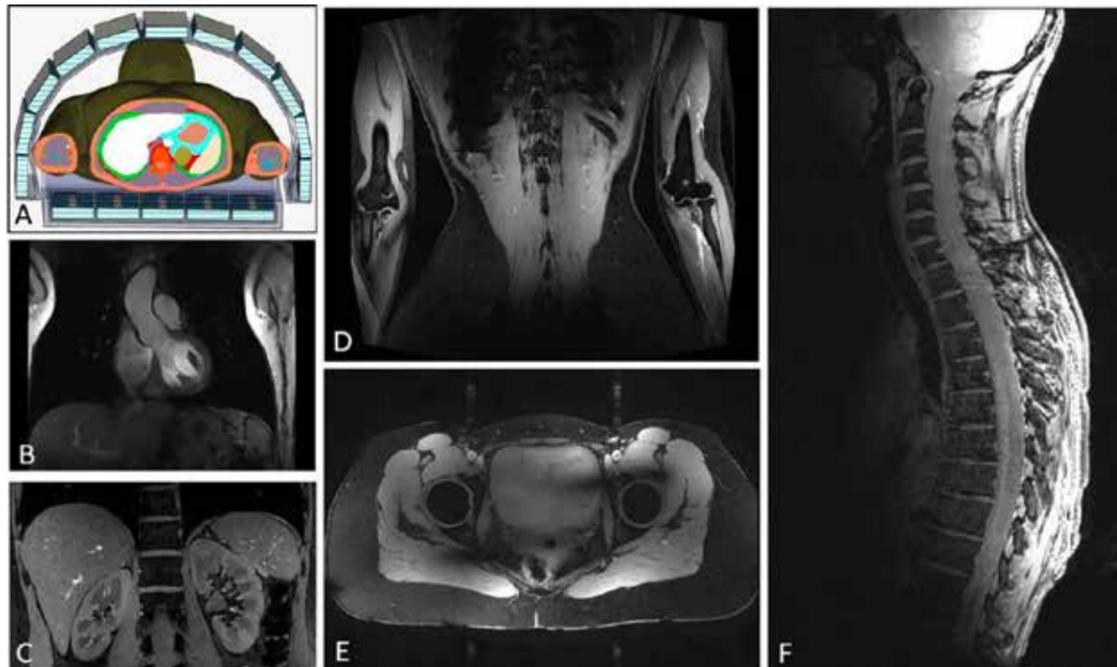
(A) Custom-built 16-channel radiofrequency (RF) transmit/receive body coil for body-MRI at 7 Tesla. Images (B-F) show current examples for 7 Tesla highfield body-MRI, employing different body regions: (B) cine-TrueFISP of the heart, (C-F) gradient-echo images of the kidneys (C), the upper body stem (D), the pelvis (E), and of the spine (F) featuring a two-step examination. All images courtesy of Erwin L. Hahn Institute for MRI, University of Duisburg-Essen, Essen, Germany
